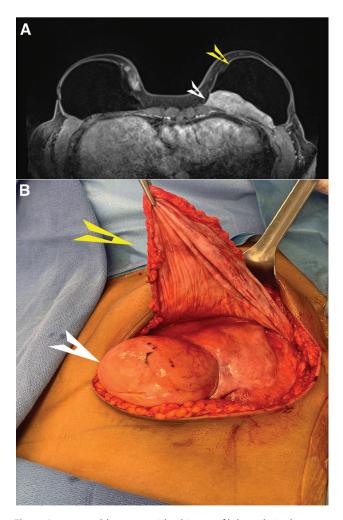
A 33-year-old woman with a history of bilateral nipple-sparing mastectomy, subpectoral implant reconstruction, and a large 9-cm desmoid chest wall tumor. A, Magnetic resonance image of a desmoid tumor (white arrowhead) and breast implant (yellow arrowhead). B, Pectoral flap raised (yellow arrowhead) using an extension of the previous inframammary fold to expose the desmoid tumor (white arrowhead) after the implant was removed.
